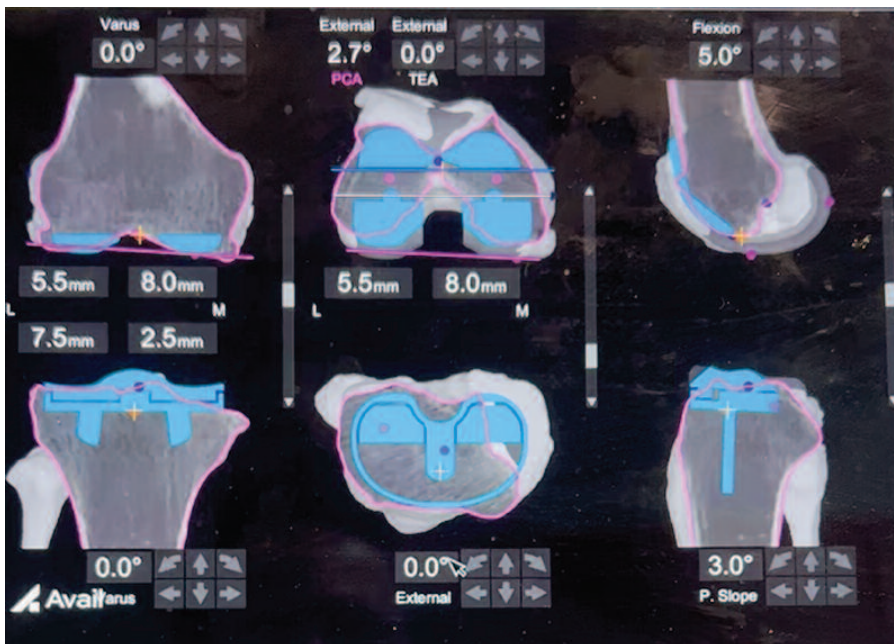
Preoperative screen demonstrating femoral and tibial component positions, rotations, and coronal/sagittal alignments based upon the preoperative computed tomography scan.
